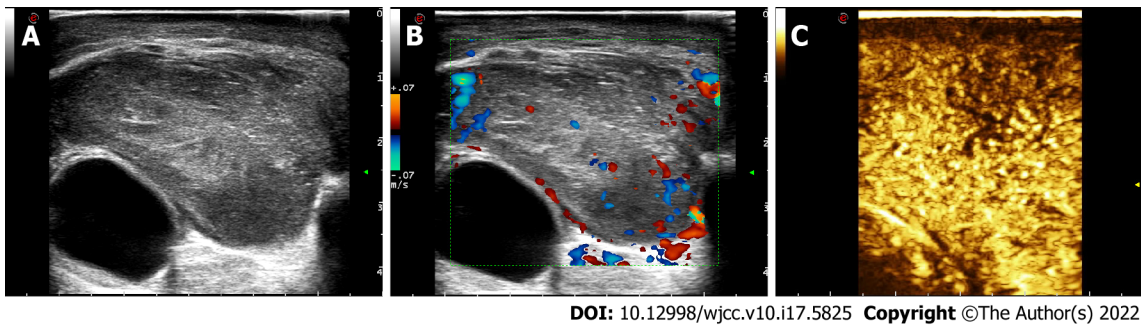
Preoperative sonography of the eyelid mass. A: Preoperative ultrasonography of the eyelid mass; B: Colour Doppler flow imaging showed the mass was rich in blood flow signals; C: Marked contrast enhancement of the mass was observed via contrast-enhanced ultrasound.
